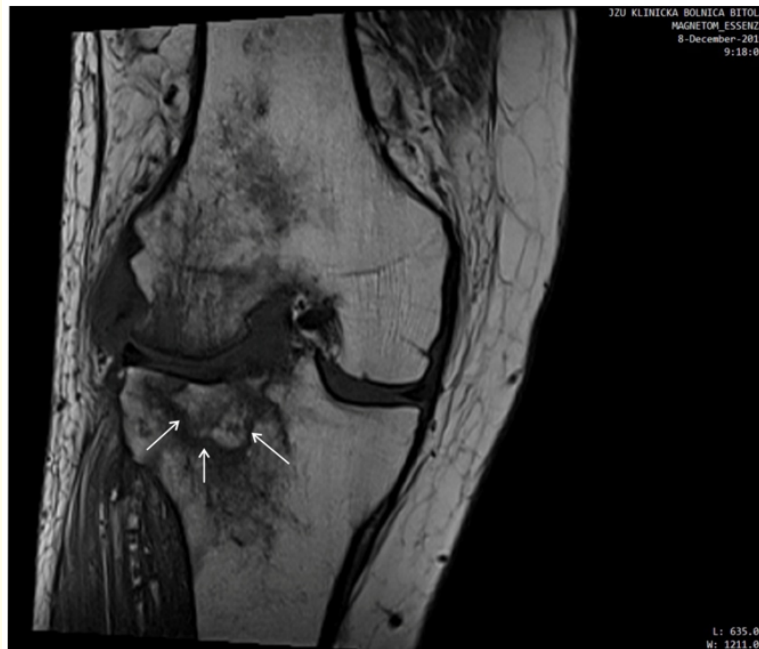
MRI coronal plane scan of the tibia 19 days after the time of the initial injury.
